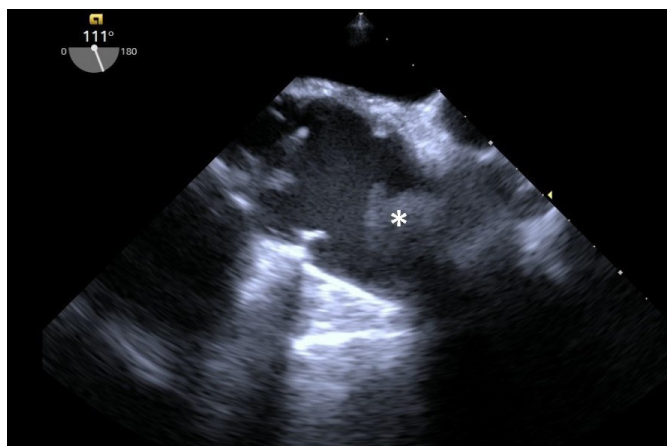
Transesophageal echocardiography showing the mass (*) in the ascending aorta.
